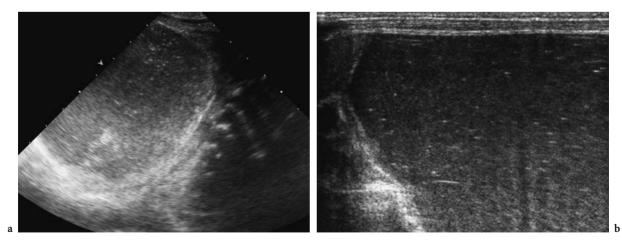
Meconium pseudocyst. a Sonography of the right hemiabdomen shows a large fluid-filled mass with echogenic contents. b High resolution US scan demonstrates a well-defined walled cyst with striking echogenic content consistent with inspissated meconium
